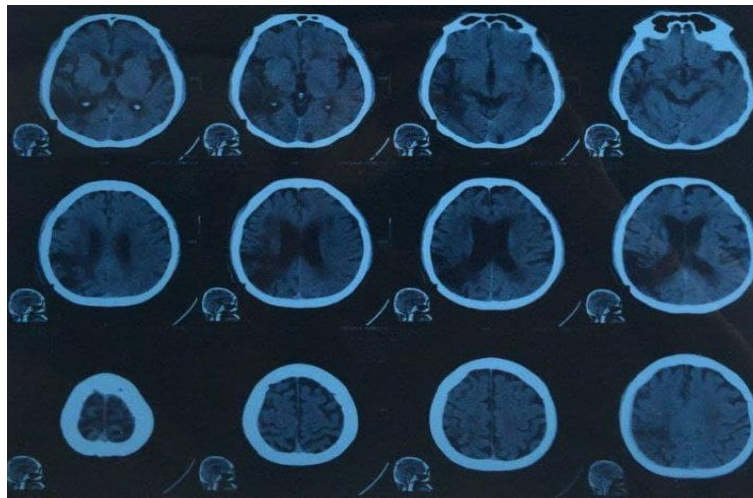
A Head CT scan without contrast showed a hypodense picture in the right temporoparietal lobe.
